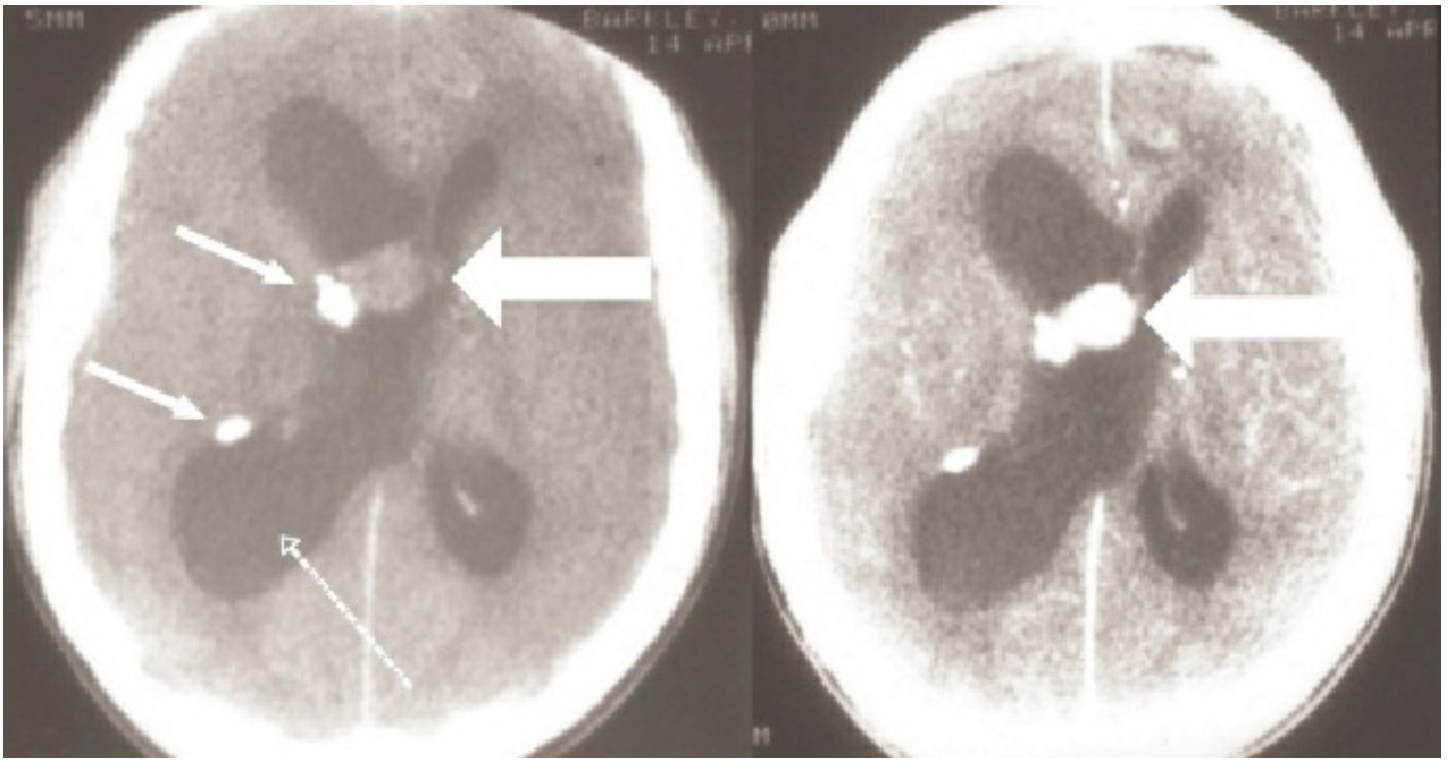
Pre- and post-contrast axial CT scan showing SGCT enhancing (large arrow in both pictures). This is causing hydrocephalus on one side (dashed arrow). SENs are also seen in the right ventricle (thin arrows). These are calcified.. The options here would be to excise the SGCT or to insert a ventriculoperitoneal shunt on the right side.
